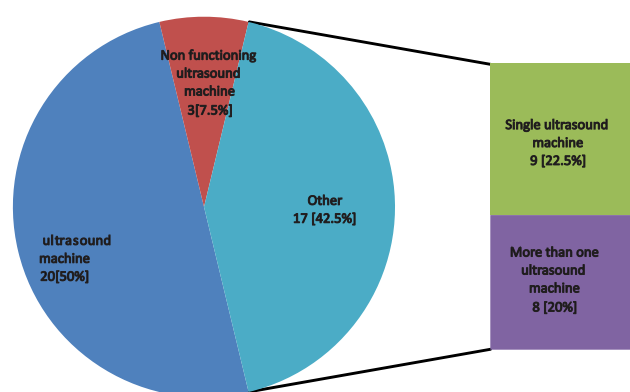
Distribution of tertiary training centers with respect to Obstetric department-domiciled ultrasound machine.
